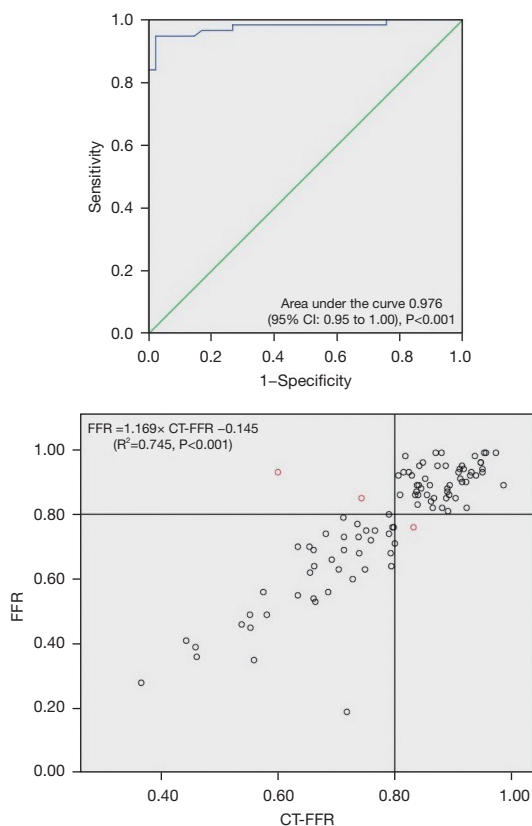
Diagnostic accuracy of resting CT-FFR versus FFR. Black circle means that the test result of CT-FFR is consistent with that of FFR; red circles means that they are inconsistent. CT-FFR, computed tomography-derived fractional flow reverse.
